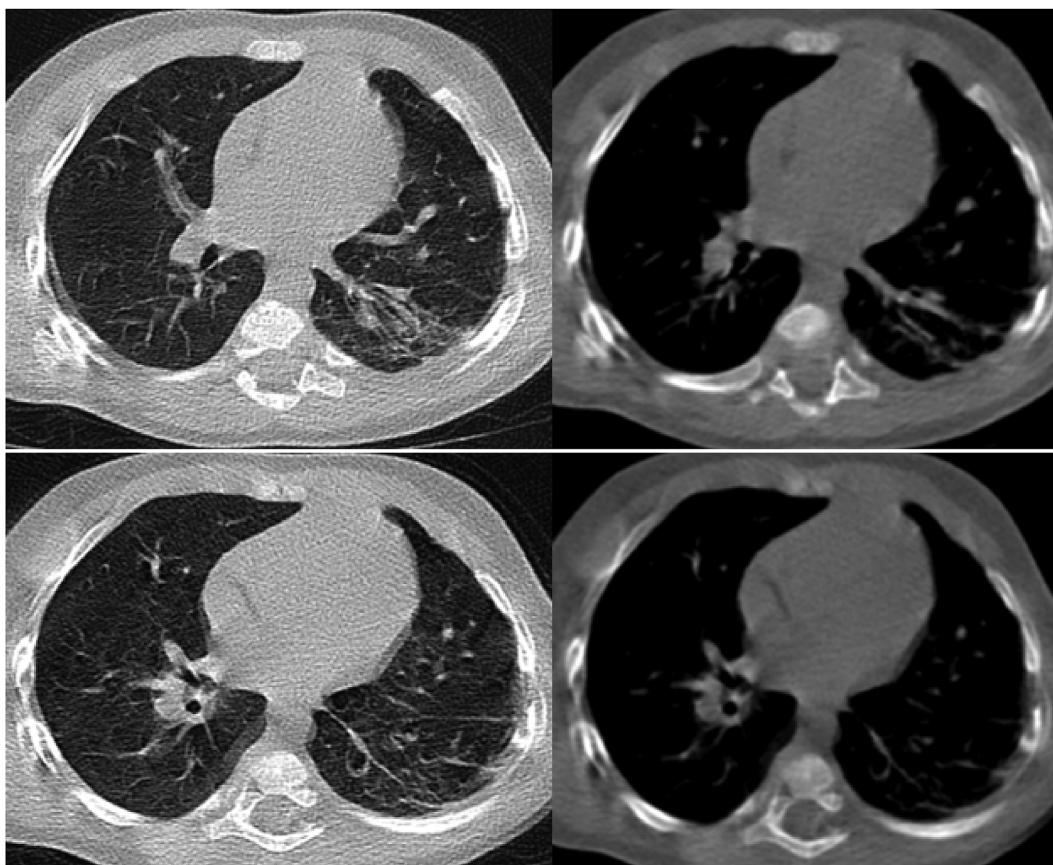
Chest-CT 1 year post-surgery: complete resolution. Re-expansion of the residual segments of the left lower lobe, showing only some fibrotic bands and traction bronchiectasis, due to parenchymal and pleural scarring.
